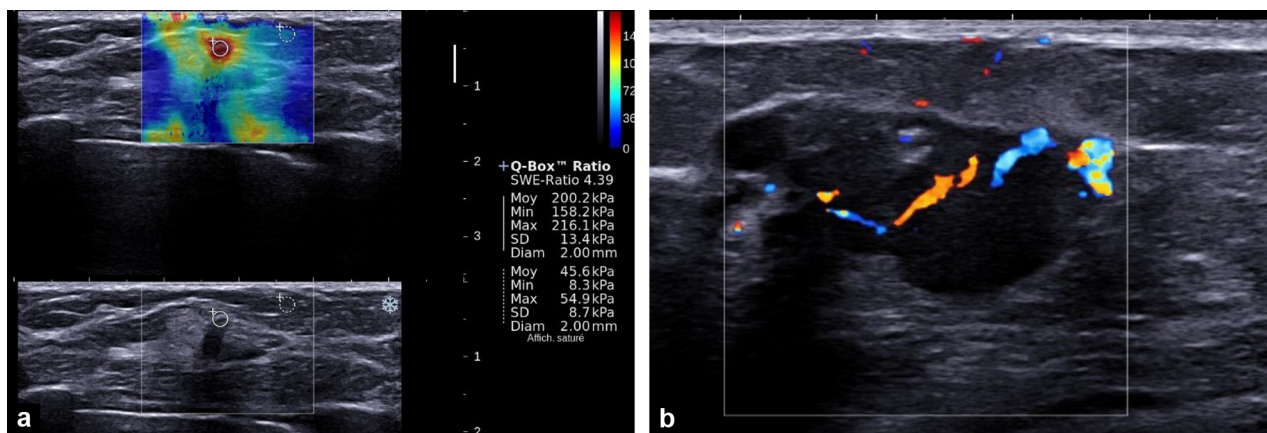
Sonography aspects as a function of the tumour grade. a: infiltrating ductal carcinoma grade I. Sonogram: masse with a centimetric hypoechoic centre surrounded by a very hard echogenic halo in elastography (200 Kpa), ACR5; b: infiltrating ductal carcinoma grade III. Sonogram: very hypoechoic, oval mass with a circumscribed edge, with posterior enhancement, vascularized, ACR 4.
